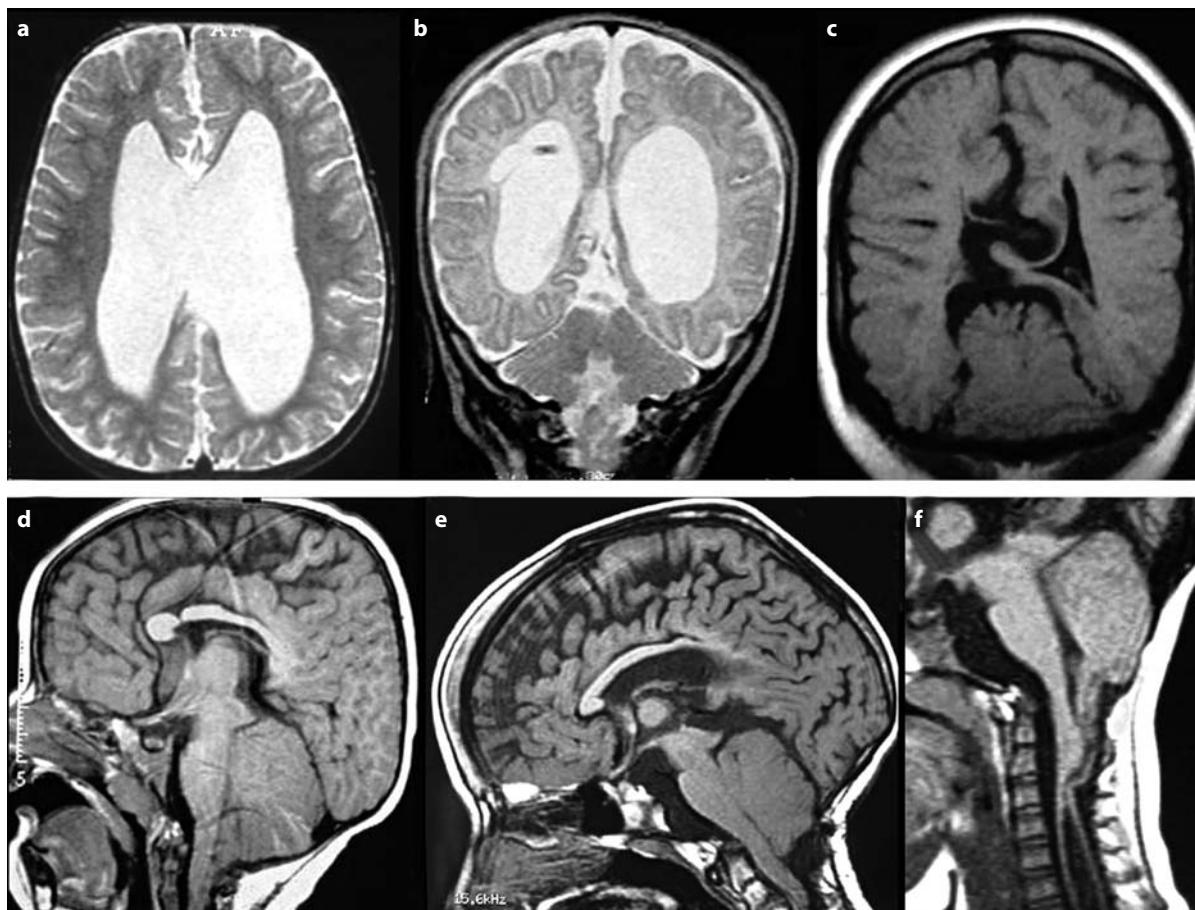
a-f. Radiological features of hydrocephalus associated with myelomeningocele. a T2-weighted axial and b T2-weighted coronal views demonstrate a huge ventricular dilatation with disproportionately enlarged occipital horns. c Post-operative T1-weighted coronal view shows the reduction in ventricular volume and the abnormal shape of the midline cerebral cortex. d-f T1-weighted sagittal images demonstrate the small posterior fossa and the descent of the cerebellar tonsils and inferior vermis into the spinal canal, as well as the upward herniation of the superior vermis associated with other typical aspects of the Chiari II malformation (beaking of the tectum; thinned and malformed corpus callosum; large massa intermedia; stenogyrus appearance of the occipital cortex; etc). f Note also the associated hydromyelia
